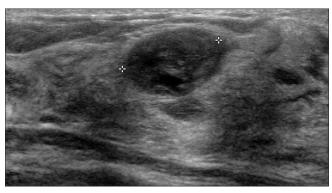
Breast ultrasound. Hypoechoic, well defined, and encapsulated lesion. BIRADS category E4a
